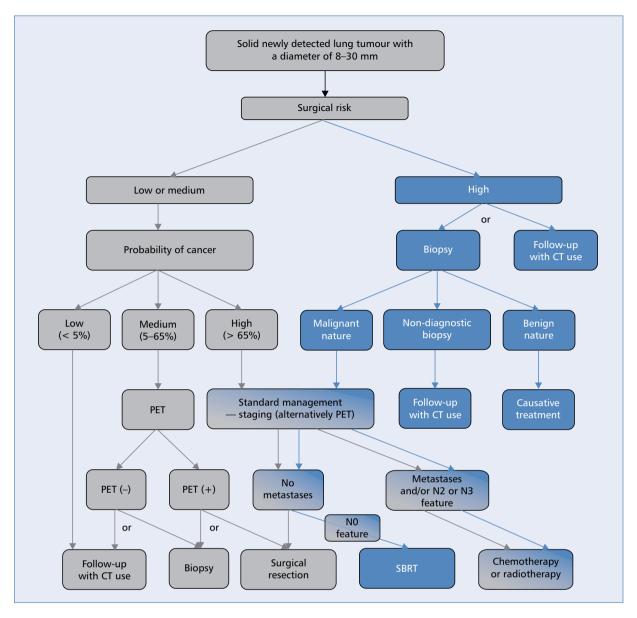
Guidelines for management in case of detection in chest CT scan a solid lung nodule with a diameter of 8–30 mm [13]. PET — positron emission tomography; CT — computed tomography; SBRT — stereotactic body radiation therapy
